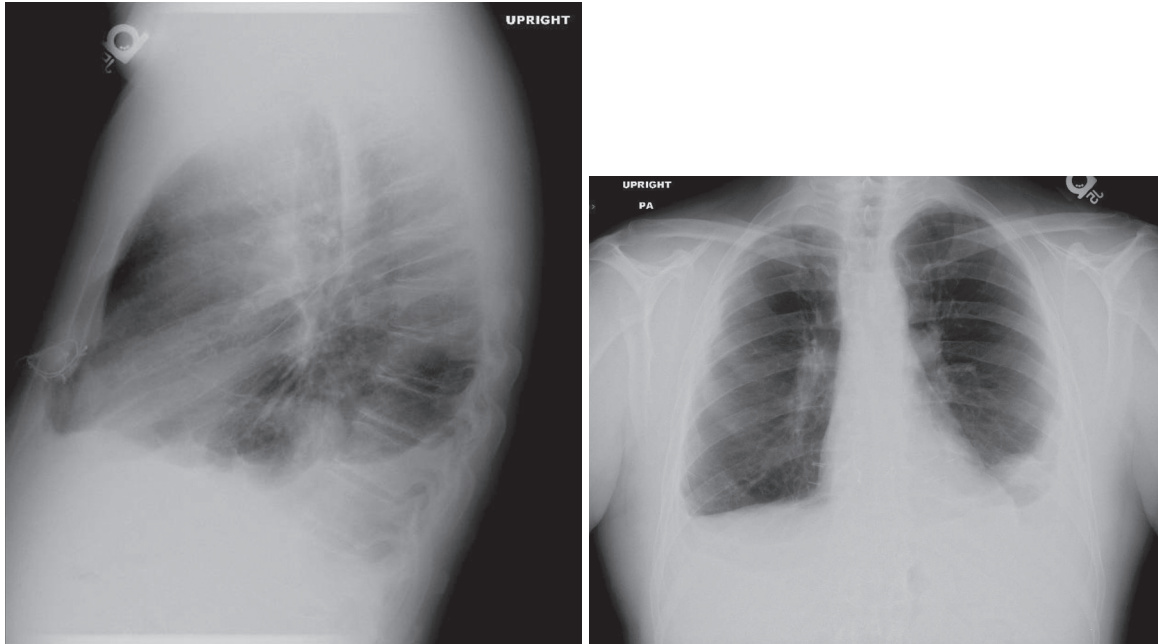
Chest radiographs showing a large left pleural effusion in a patient with *Klebsiella pneumoniae* pneumonia.
